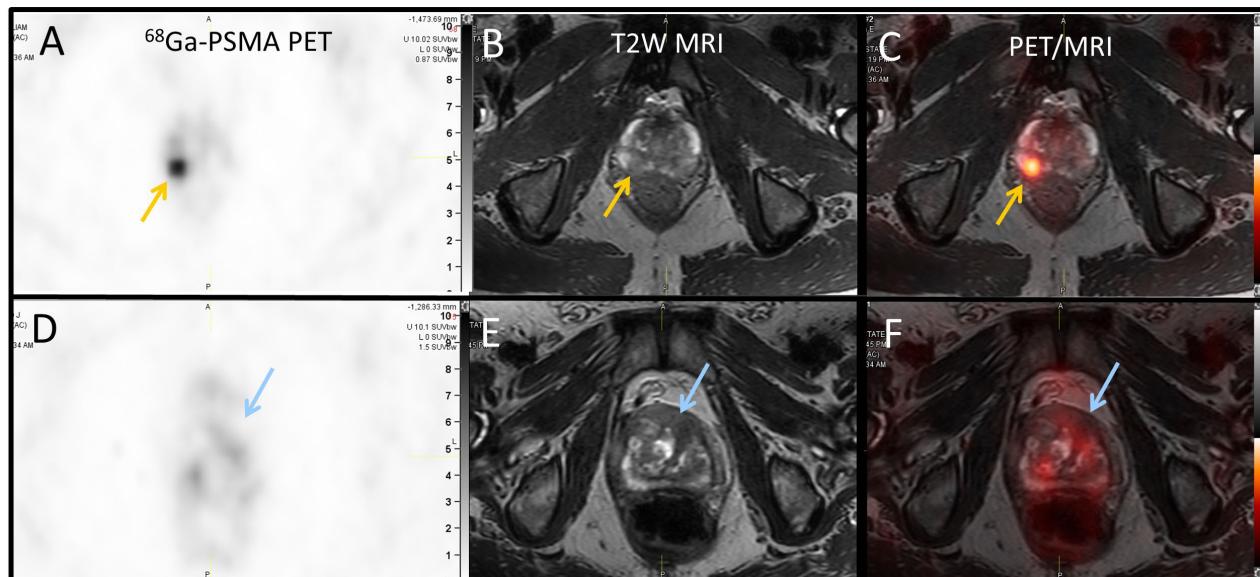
Co-registered axial ^{68}Ga -PSMA PET (A,D; SUV range 0 – 10 for both scans), T2W MRI (B,E) and PET/MRI (C,F) of two subjects for which a mpMRI resulted in a PI-RADS 5 lesion. Upper panel (A-C), case 1: Gleason 4+3 cancer at the right apex (orange arrows), identified at targeted biopsy with intense focal ^{68}Ga -PSMA uptake (SUV median 7.0). Lower panel (D-F), case 2: targeted biopsy resulted in active and chronic granulomatous inflammation (blue arrows) without elevated ^{68}Ga -PSMA uptake (SUV median 1.4).
